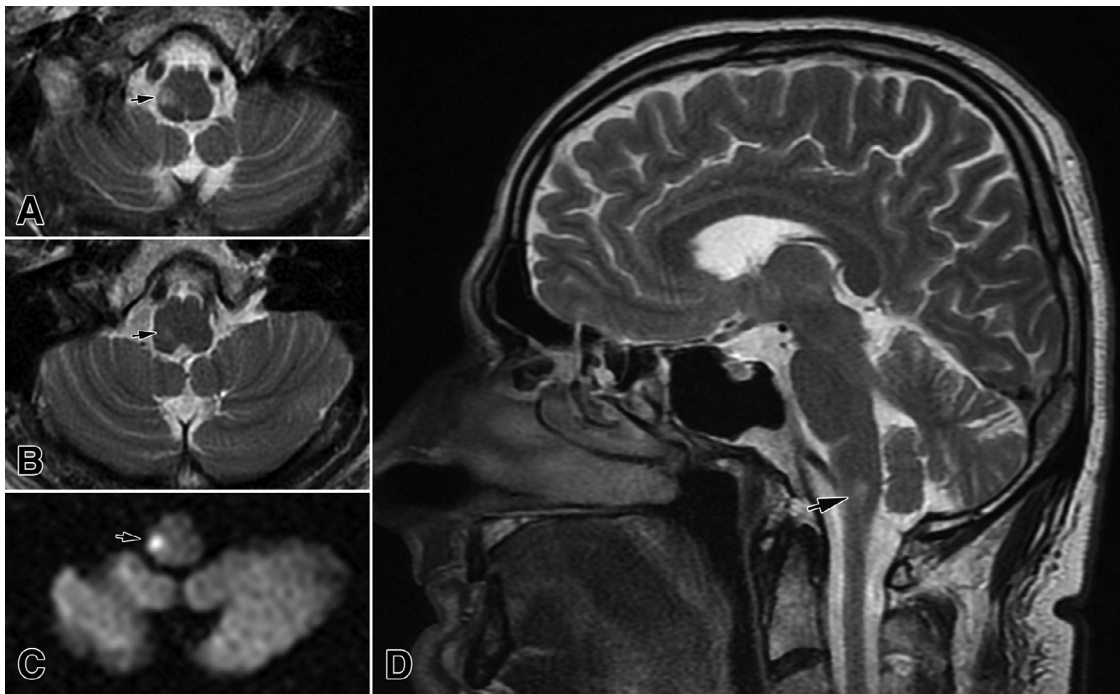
A right incomplete lateral infarction (arrows) of the lower and middle medulla, mainly affecting the posterior part of the lateral vascular territory. It is presented in the axial T2-weighted (A and B) and DWI (C) images, as well as in a sagittal T2-weighted image (D).
